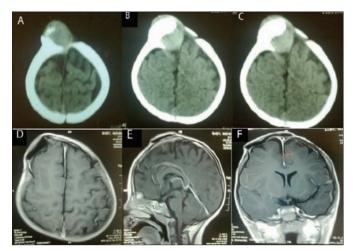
A,B,C: Pre-operative CT scans of the patient showing an iso to hypo dense lesion with reactionary bony enlargement, and which was compressing the superior sagittal sinus. D,E,F: Postoperative contrast enhanced T1 images showing complete tumour excision without recurrence.
